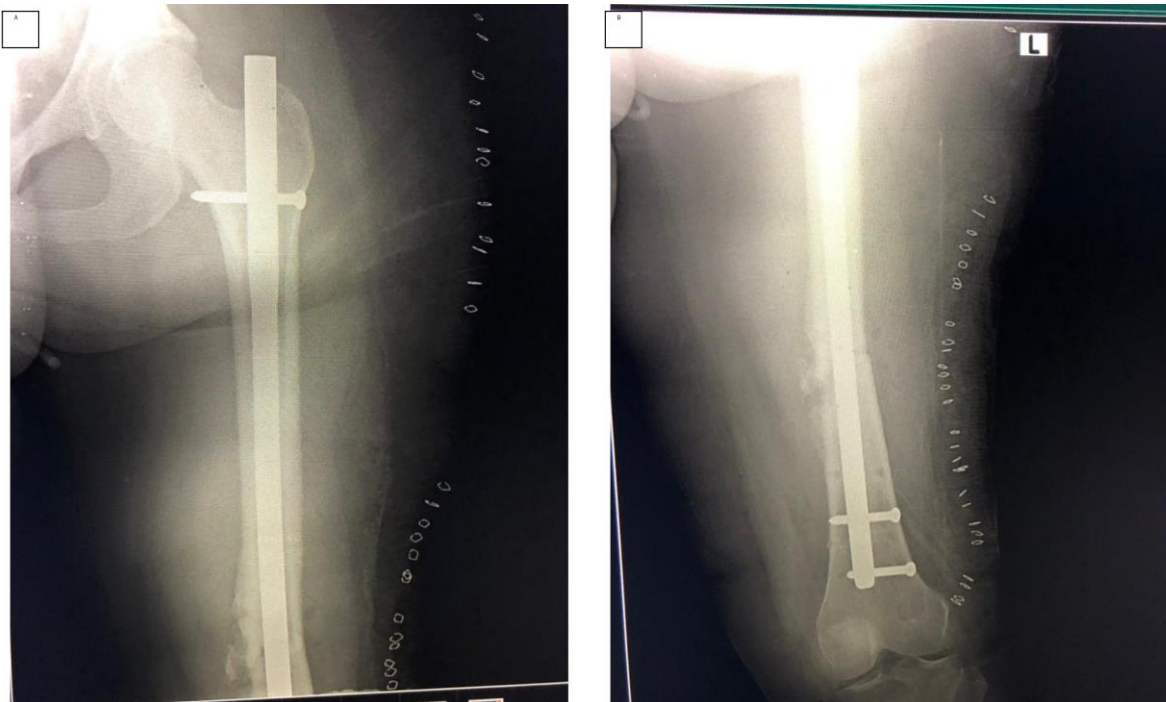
Immediate postoperative radiographs following removal of the deformed implant and revision locked intramedullary fixation. (A) Long-segment view. (B) Distal femoral view.
